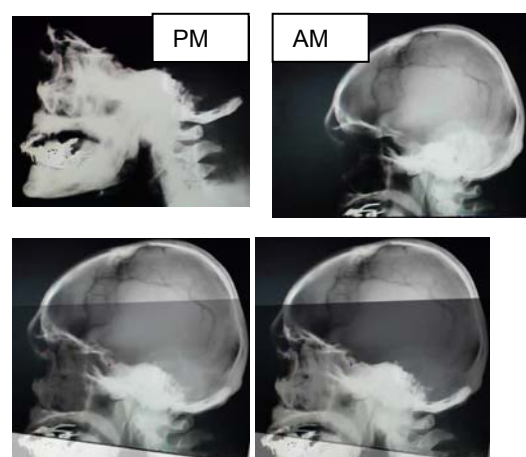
Upper on the left the PM lateral x-rays of the skull that denotes the severe destruction of cranial bones. On the right the AM lateral x-rays of the skull that reproduced only the neurocranial part of the skull. Lower the superimposition of the images (35% and 55% of transparency) that shows the perfect correspondence of the cranial base profiles.
